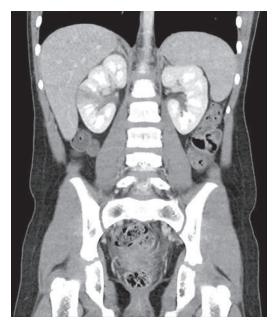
Acute pyelonephritis seen as an area of decreased perfusion by CT scan done for abdominal pain and fever in a child who subsequently was shown to have no reflux by VCUG.
